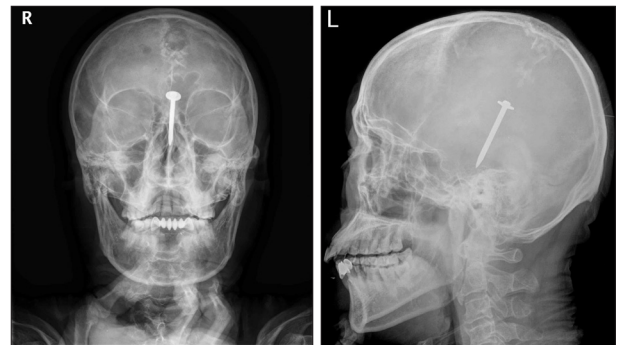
Preoperative simple radiographs show the nail passing through the left parietal calvarium deep to the proximal brainstem.
